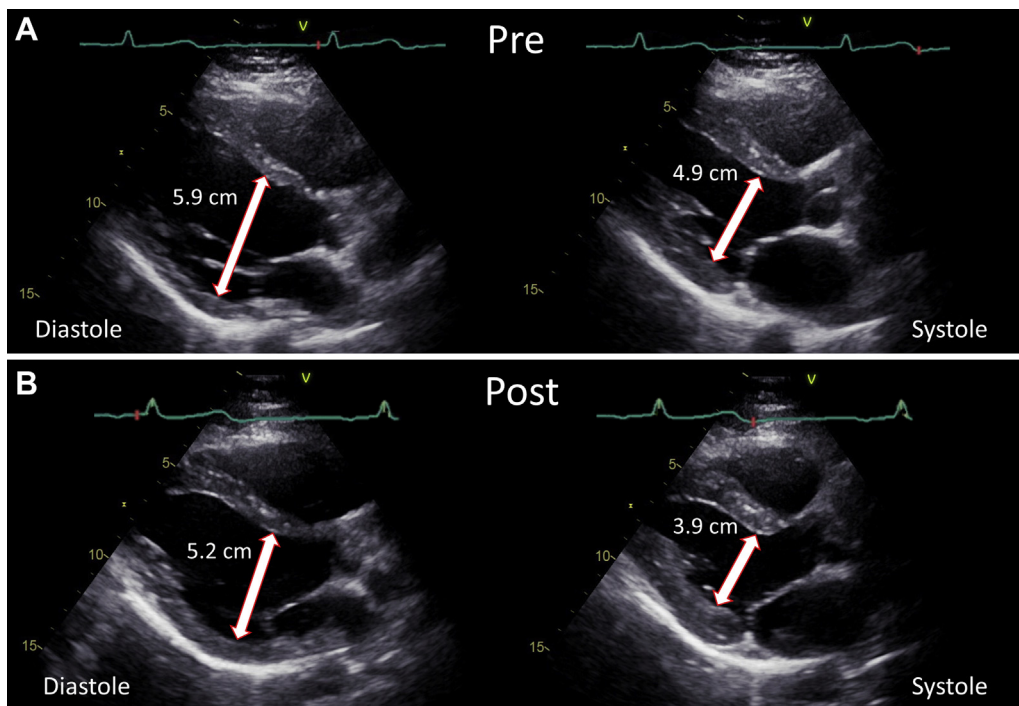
Transthoracic echocardiography before and after ablation. Samples of parasternal long-axis images from transthoracic echocardiography before and after radiofrequency ablation of premature atrial contractions. A: The preablation left ventricle (LV) was dilated, with end-diastolic diameter of 5.9 cm, and demonstrated depressed ejection fraction of 40%. B: After ablation, there was improvement in LV dimensions, with end-diastolic diameter decreasing to 5.2 cm, and LV ejection fraction improved to 50%.
